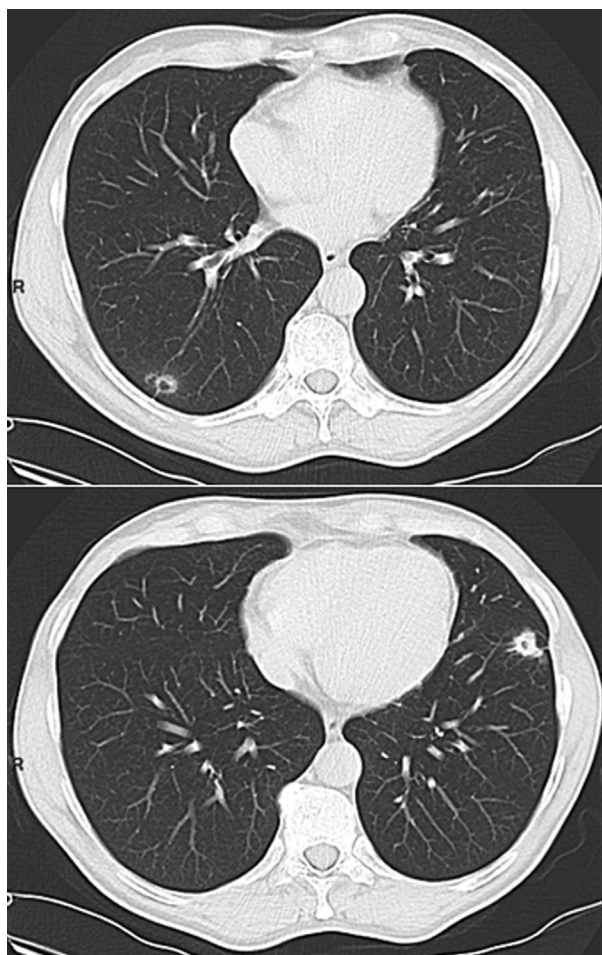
Chest CT scan shows multiple and disseminated pulmonary nodules with cavitation.
